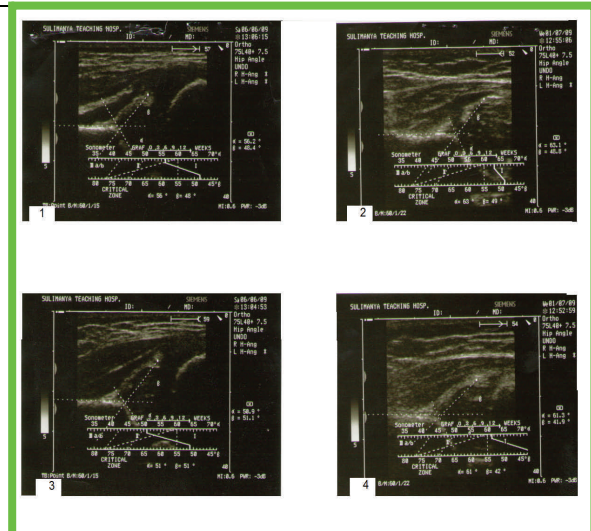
ultrasound of the hip shows bilateral Graf IIa at first week of age (1 and 3) changed to Graf I bilaterally (2 and 4) without treatment (only triple napkins) after three weeks indicating physiological immaturity.
